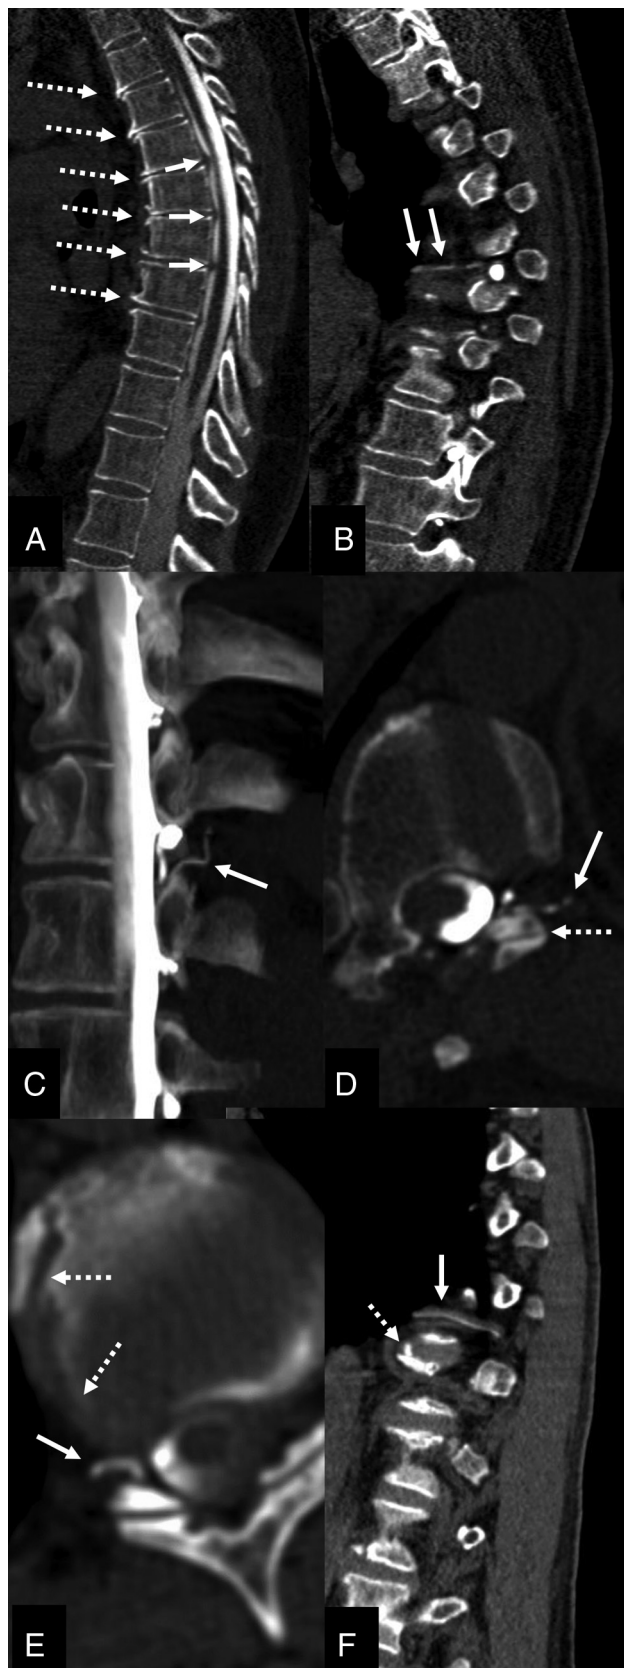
Three patients with osteoarthritis at the level of their CVFs. *Upper row.* A 66-year-old woman with intracranial hypotension and a right T7–T8 CVF. A, Midline sagittal CT image from dynamic myelography demonstrates anterior endplate osteophytes clustered from T4–T5 through T9–T10 (dashed arrows) and disc protrusions at T6–
